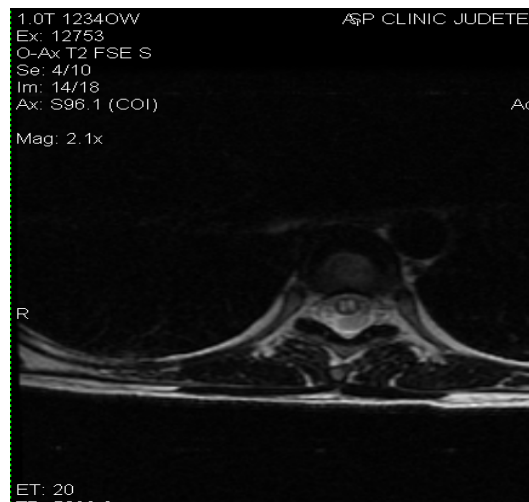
MRI reveals an H-shape pattern involving the central grey matter and near T12 level we observe a more diffuse pattern involving both gray and white matter.
